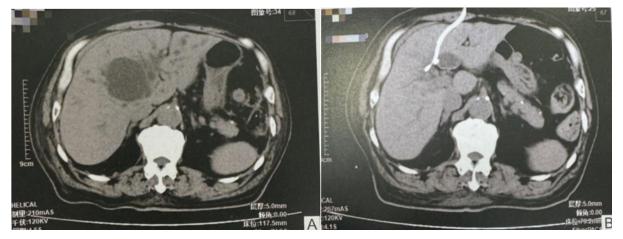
Figure A Preoperative CT showed hepatic cyst and intrahepatic bile duct dilation. Figure B CT scan after punture showed hepatic cyst collapse with no significant dilation of the interahepatic bile duct.
